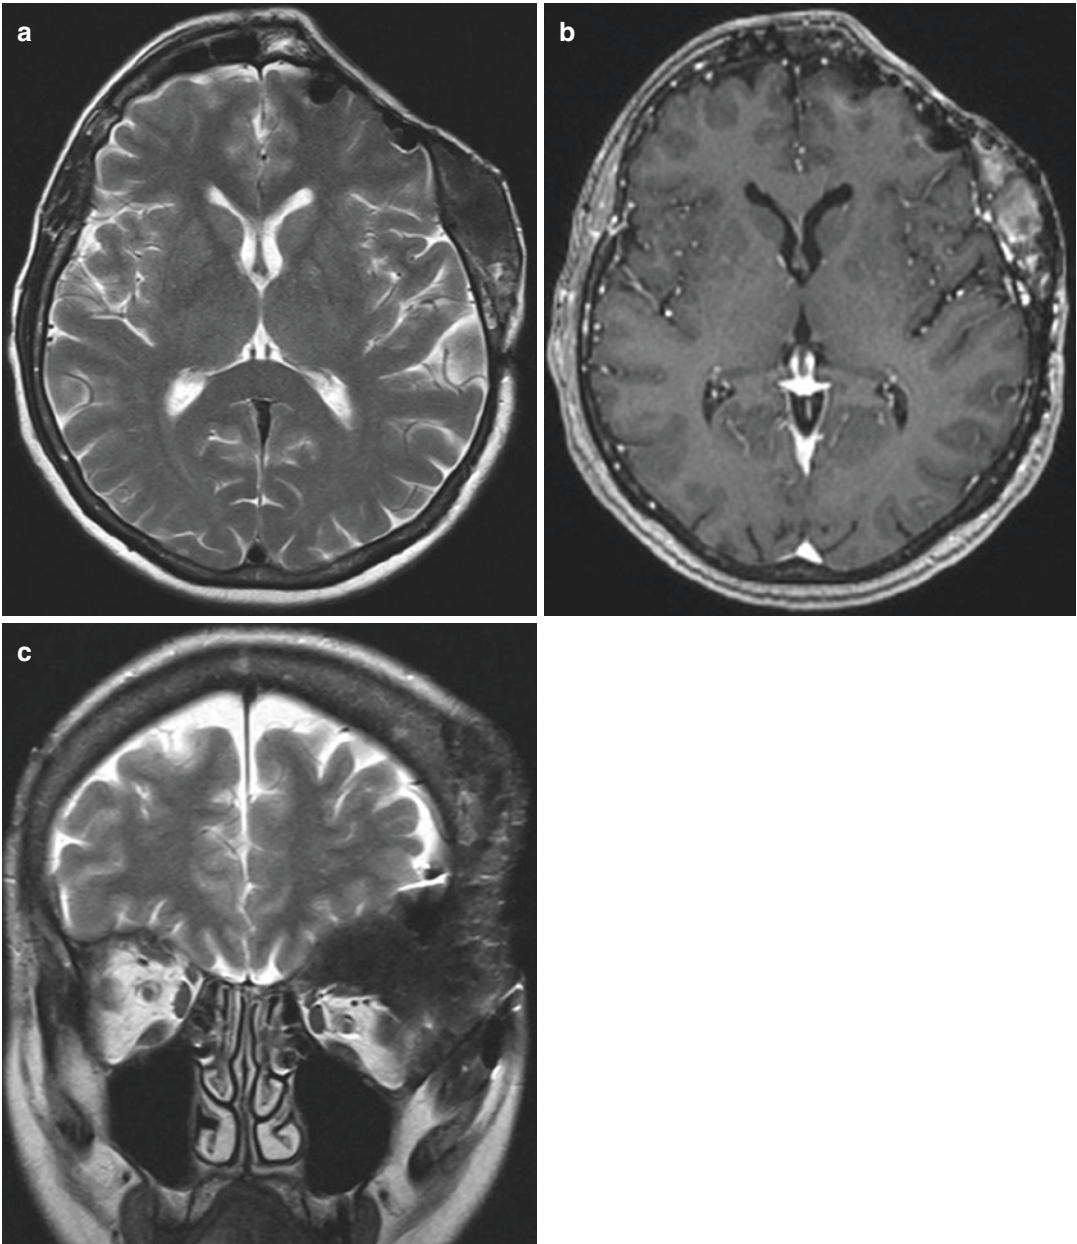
Postoperative MRI of the head—axial T2WI (a), axial post-contrast T1WI (b), coronal T2WI (c). There are postoperative bony defects and characteristic post gadolinium enhancement of the remaining dysplastic bones (b)
